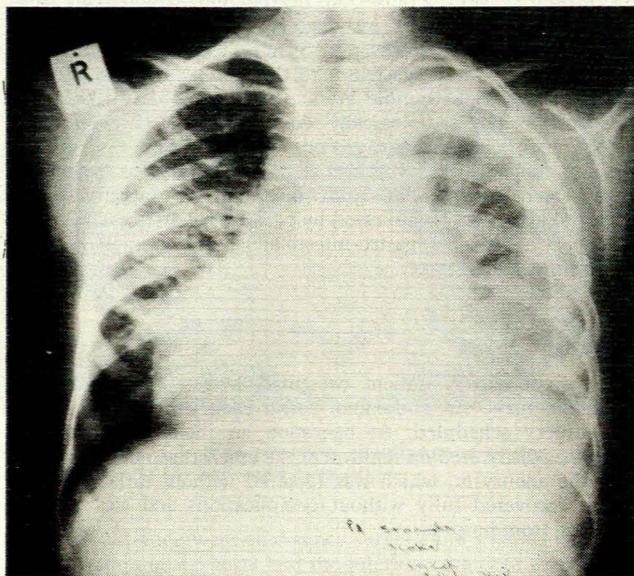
Case 1. Chest radiograph showing cardiomegaly and pleural effusion.
